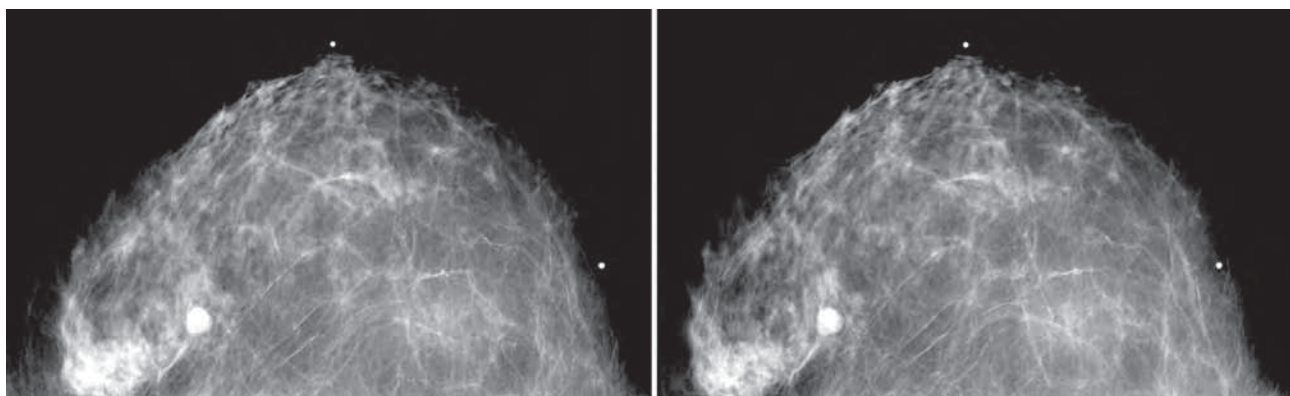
Stereo pair of digital mammograms acquired on a preclinical version of a digital mammography unit. The x-ray source was rotated by 6° between the two exposures ($\pm 3^\circ$ either side of the perpendicular to the detector surface). Although the two images look similar, different amounts of horizontal parallax are present for corresponding points at different depths in the imaged breast tissue. It is possible to experience the fused stereo image by crossing one's eyes. A benign mass is seen on the mammogram at 8 o'clock. When viewed in stereo, the location and orientation in depth of the many strands of fibrous tissue and vessels become readily apparent.
